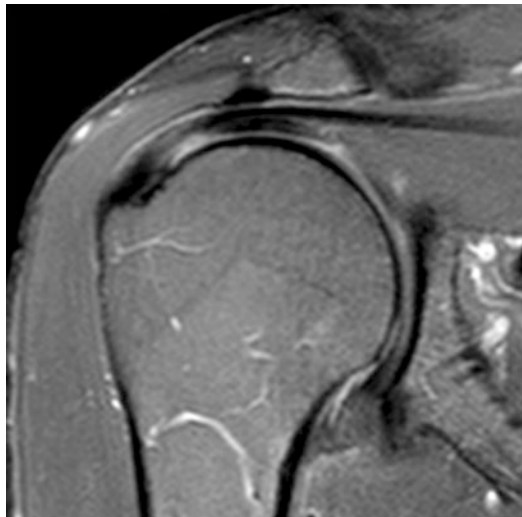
MRI of Partial tear of the supraspinatus tendon. (With permissions from Guilherme Grisi Mouraria)
